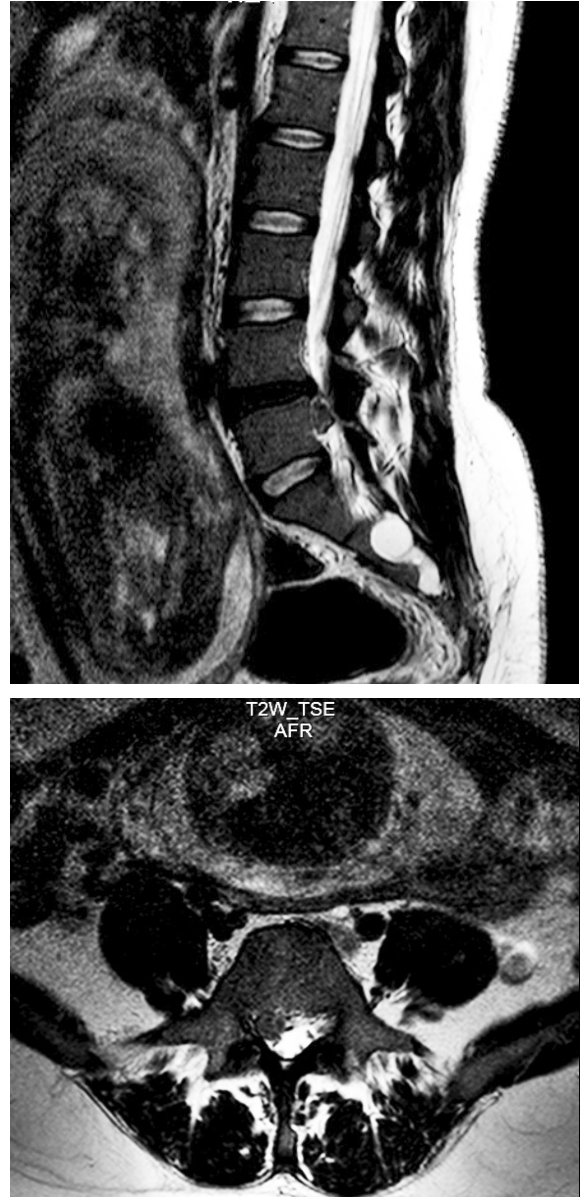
Case 1.1, 2 Lumbar MR images preoperatively.
